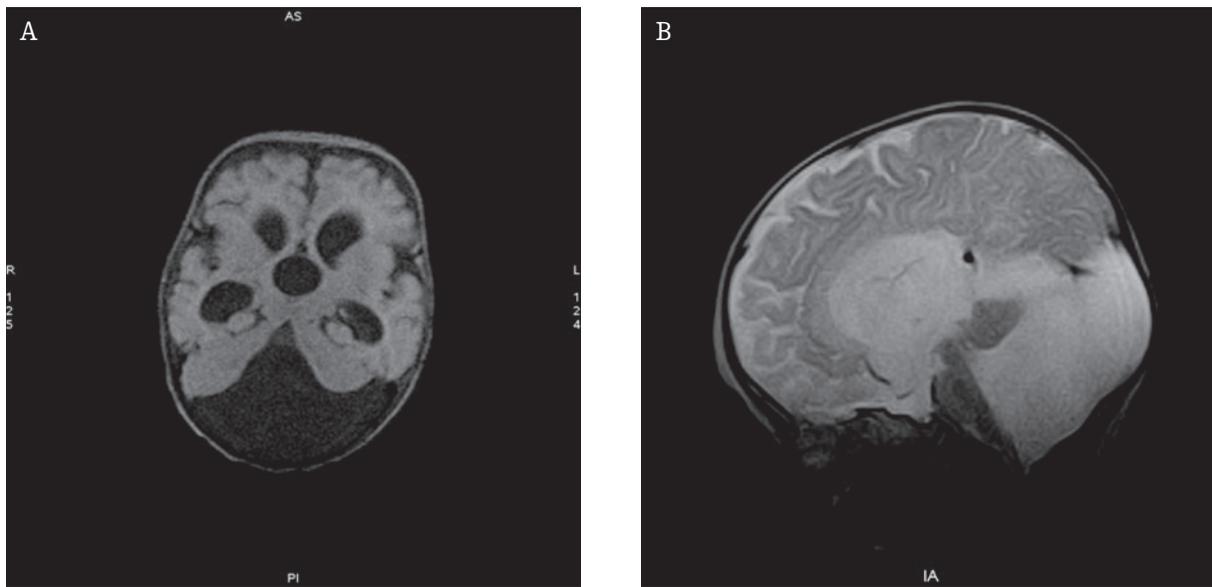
Dandy-Walker malformation (DWM). Axial MRI FLAIR (A) and saggital T2-weighted (D) images show the classic triad of symptoms: marked hypoplasia of the vermis, cystic transformation and extension of the fourth ventricle (which bulges posteriorly, displaces and elevates the cerebellar vermis and fills almost the entire posterior fossa of the cranium) as well as posterior fossa enlargement with accompanying upward displacement of the dura mater sinuses and cerebellar tentorium.
